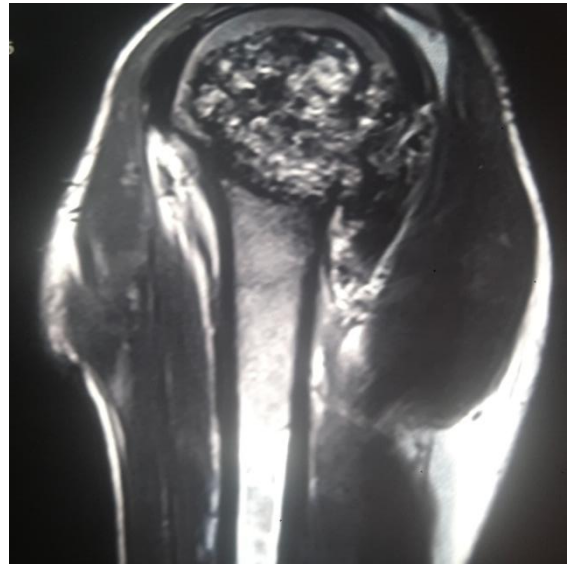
CT scan showing mass arising in the epiphysis of the humeru
